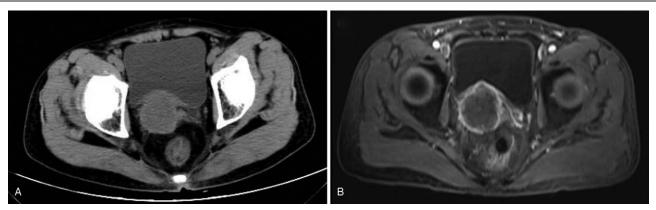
Computerized tomography scan (A) and magnetic resonance imaging (B) demonstrated a 40mm×45mm×48mm mixed solid/cystic tumorous lesion with nonhomogeneous density and obscure boundary in the right seminal vesicle.
